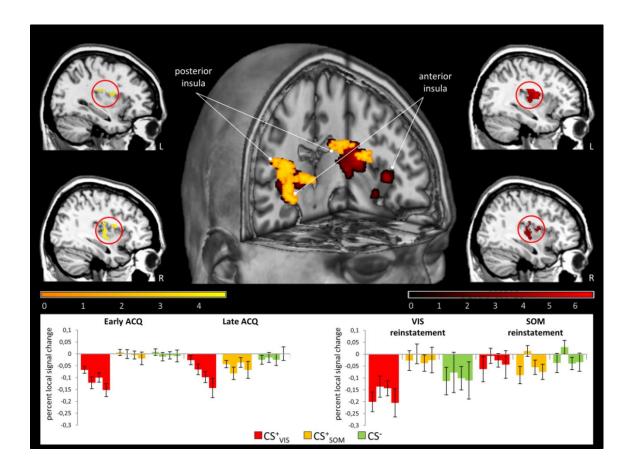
Overlap in the insula for CS⁺_{VIS} compared to CS⁺_{SOM} in different learning phases. Differential neural activation during early acquisition (yellow-orange) and after visceral reinstatement (dark red-light red) in anterior and posterior insular regions for the visceral compared to the somatic pain-predictive CS [all contrasts: p_{FWE} < .05]. Bottom panel depicts percent local signal changes during (left) acquisition and (right) after reinstatement. For more details on BOLD data analyses, see Tab.5 and result section (4.2.5.2. und 4.2.5.3.). Activations were superimposed on a structural T1-weighted MRI used for spatial normalization and thresholded at p<.001 uncorrected for visualization purposes. Color bars indicate t-scores. Abbreviations: ACQ, acquisition; CS, conditioned stimuli; FWE, family-wise error; SOM, somatic; VIS, visceral.
